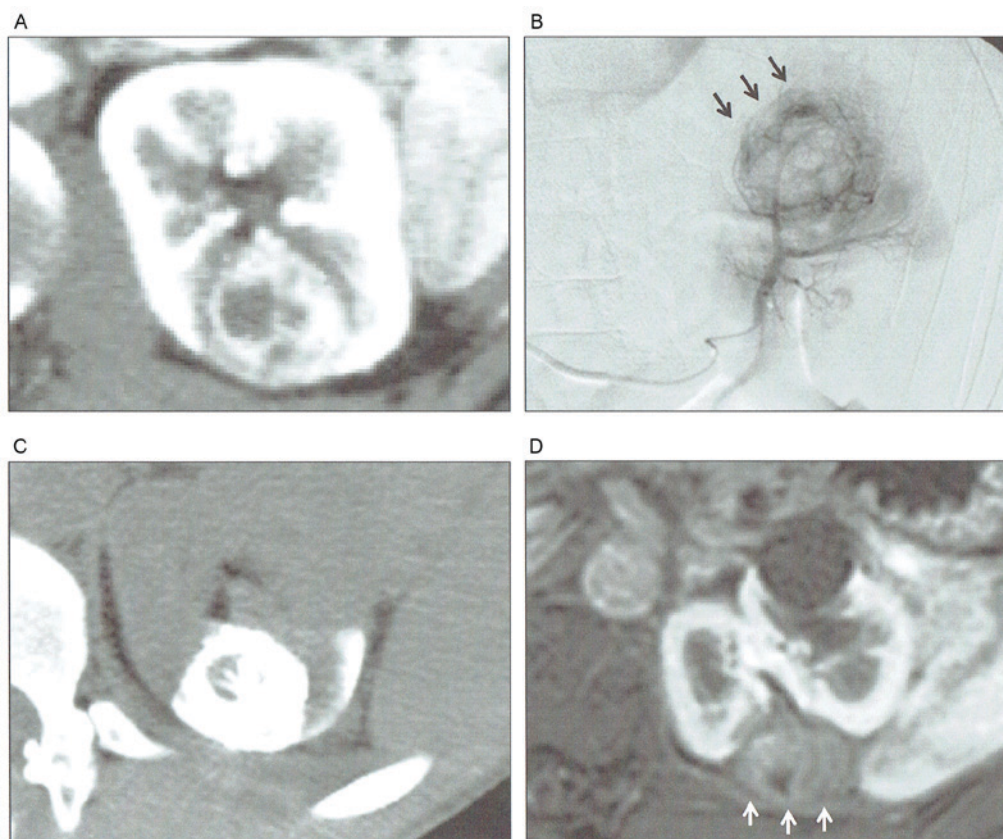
(A) CT demonstrated a parenchymal type renal tumor in the upper side of the left kidney. (B) Transarterial embolization was performed 1 day before percutaneous RFA to achieve successful ablation. Transarterial embolization theoretically decreases a vascular cooling effect and possibly improves the rate of complete ablation. (C) CT at the day of RFA. The presence of lipiodol remained at the renal tumor and the surrounding renal tissue. Owing to the presence of lipiodol, the tumor was easily targeted at percutaneous RFA. (D) Dynamic MRI 1 year after RFA. No enhancement was observed in the ablated tumor (complete ablation). CT, computed tomography; RFA, radiofrequency ablation; MRI, magnetic resonance imaging.
